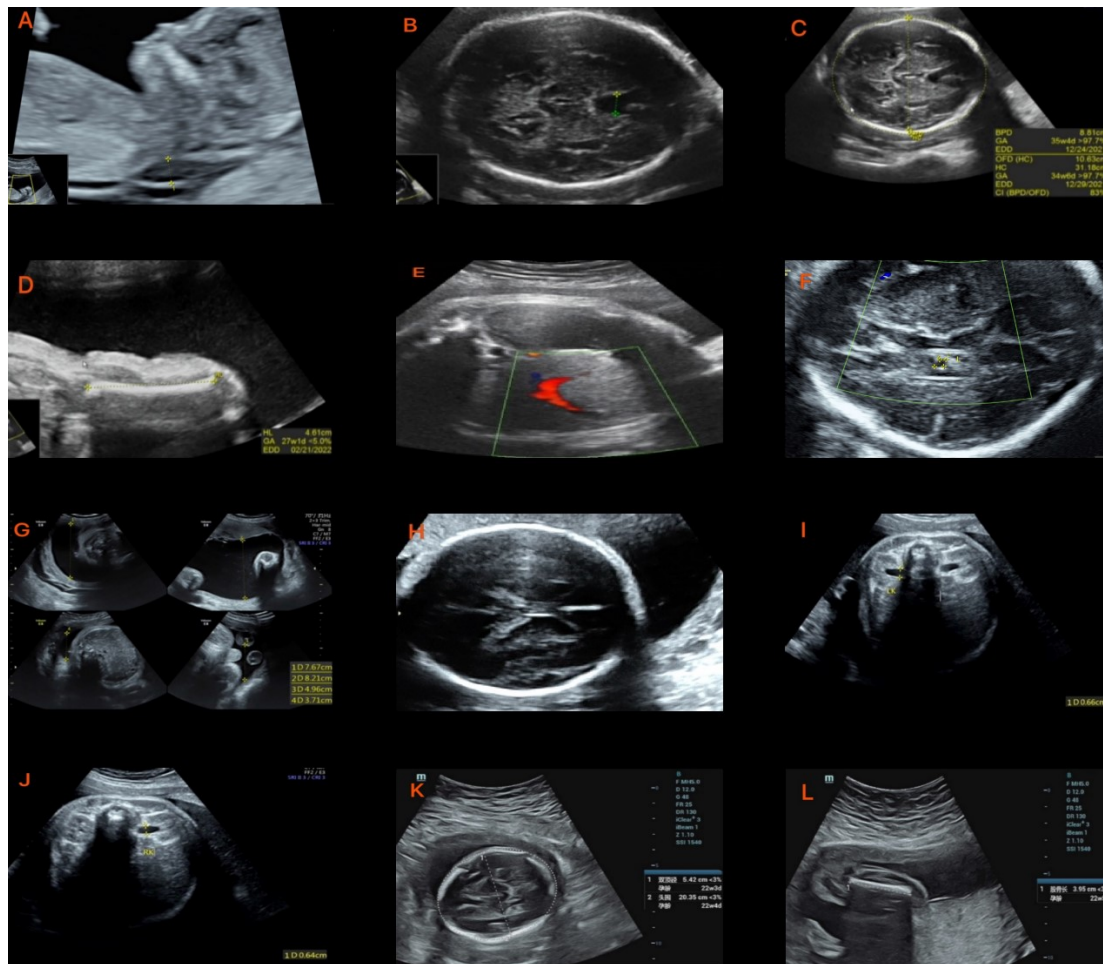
Representative standardized US and MRI findings in 5 fetuses with NS. (A) Case 1: US: nuchal cystic hygroma (12⁺⁰ weeks, thickness: 8 mm). (B) Case 2: US: widened septum pellucidum (31⁺⁰ weeks, 3 mm, Z-score = 2.3). (C) Case 2: US: macrocephaly (biparietal diameter and head circumference >97th percentile). (D) Case 2: US: skeletal dysplasia (femur length <5th percentile). (E) Case 2: US: suspected persistent right umbilical vein. (F) Case 3: US: choroid plexus cyst (32⁺⁰ weeks, diameter: 2 mm). (G) Case 3: US: polyhydramnios (32⁺⁰ weeks, AFI = 30 cm). (H) Case 4: US: unclear septum pellucidum. (I,J) Case 4: US: bilateral Grade I renal pelvis dilatation. (K) Case 5: US: FGR with microcephaly. (L) Case 4: MRI: small septum pellucidum with normal corpus callosum. All US abnormalities were defined per ISUOG 2020 guidelines; AFI, amniotic fluid index; FGR, fetal growth restriction; US, ultrasound; MRI, magnetic resonance imaging; NS, Noonan syndrome; ISUOG, International Society of Ultrasound in Obstetrics and Gynecology.
